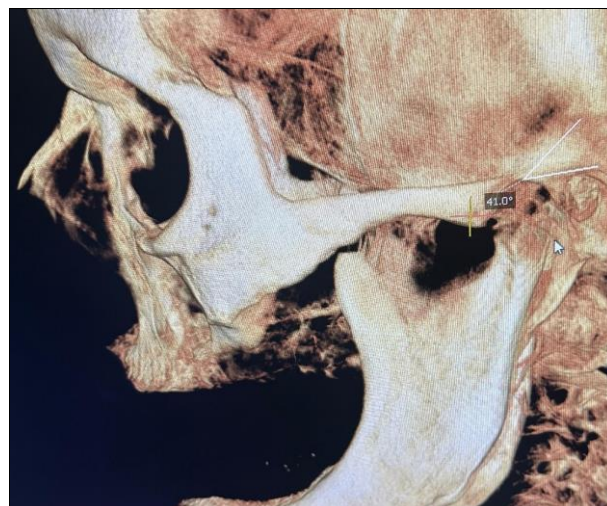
Condylar guidance angle obtained from CBCT
